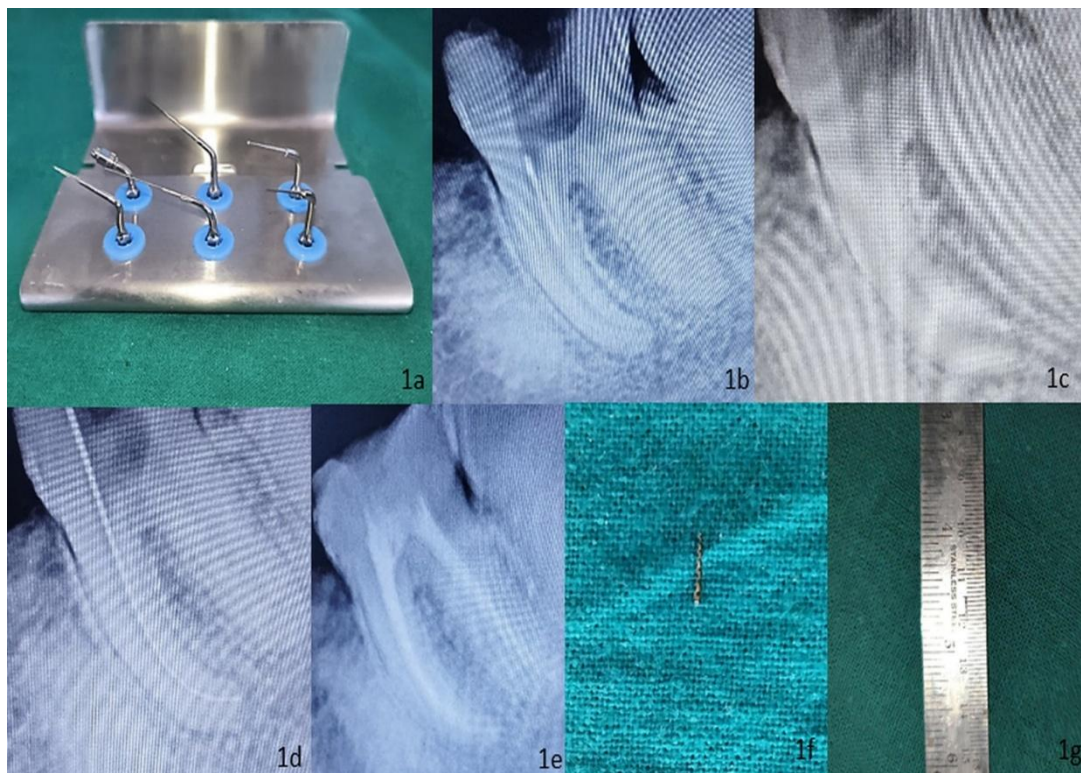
1a : Ultrasonic tips, 1b: Preoperative radiograph, , 1c : After removal of the fragment, 1d : Canal patency , 1e : After obturation, 1f and 1g : Retrieved file
